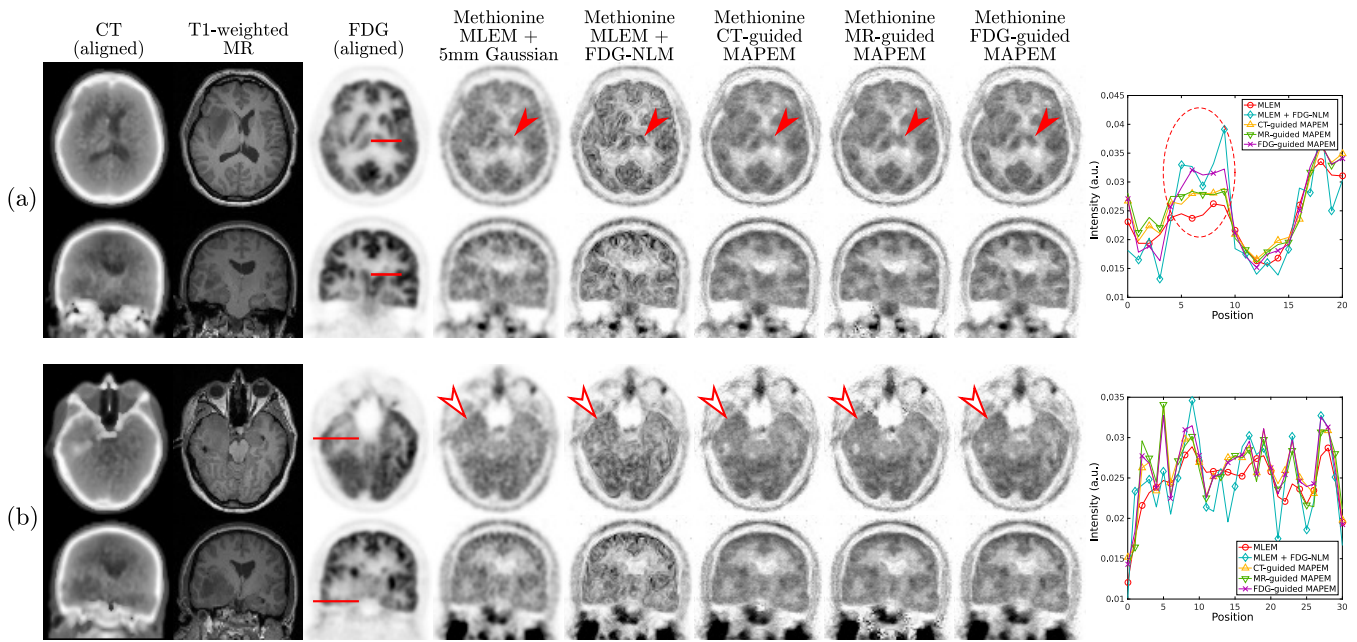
Reconstructed images for the real data preliminary study. From left to right for both (a) and (b): previously acquired CT image, aligned and resampled to the methionine image grid and contrast-enhanced using a 3D contrast limited adaptive histogram equalisation; T1-weighted MR image acquired simultaneously with the methionine PET data, resampled to the methionine image grid; FDG data reconstructed with 100 iterations of MLEM, followed by a 4 mm Gaussian smooth and then aligned into the methionine image space; methionine data reconstructed with MLEM followed by a 5 mm Gaussian smooth; the same methionine data reconstructed with MLEM and then followed by FDG-NLM filtering; the methionine data reconstructed with CT-guided MAPEM; the methionine data reconstructed with MR-guided MAPEM; the methionine data reconstructed with FDG-guided MAPEM; and methionine image profiles as indicated by the lines superimposed on the FDG reconstructions. All methionine reconstructions were run to 200 iterations, and all guided reconstructions used the baseline hyperparameter values as given in Table I. (a) Increased uptake was observed in the thalamus when using the FDG-guided MAPEM compared to the Gaussian filtered MLEM and CT- and MR-guided reconstructions (filled arrows and circled in the profile). (b) A discrepancy between FDG and methionine uptakes is apparent (unfilled arrows), however the FDG-guided MAPEM allows good reconstruction of this region without any visible cross-talk.
